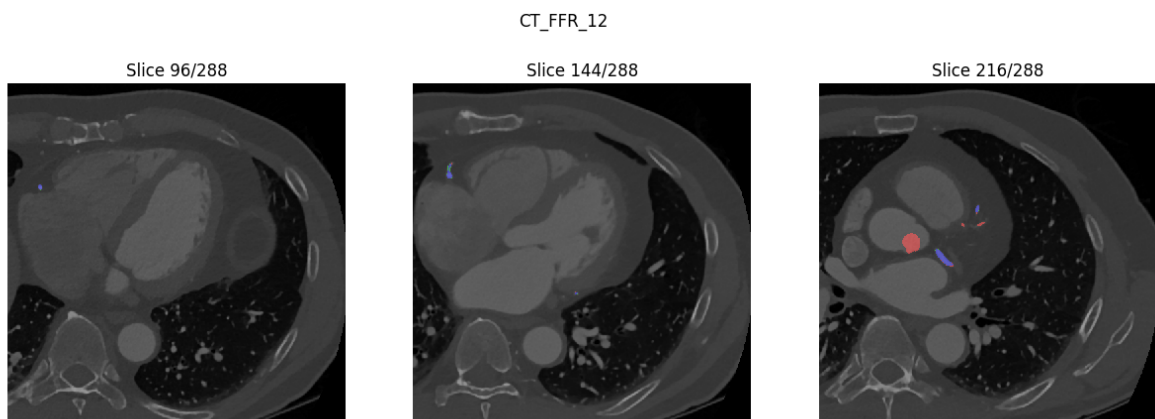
A selection of some of the CT slices of the SegCaps model’s best prediction of the coronary artery split-1, where the corresponding prediction is overlaid. The prediction is color-coded with blue=TP, green=FP, and red with low opacity=FN
